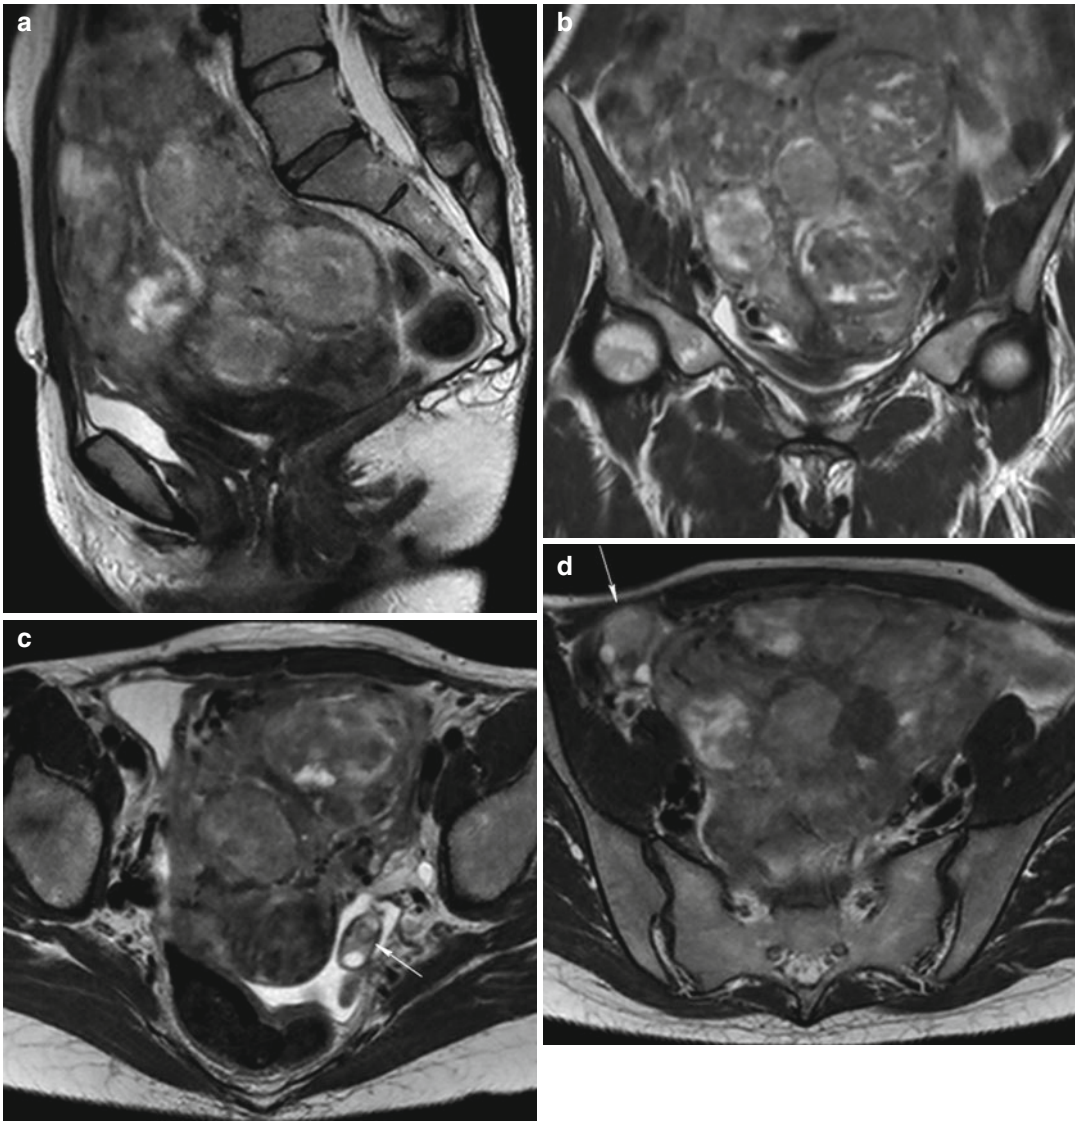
Multiple uterine leiomyomatosis. Sagittal (TR 4,800 ms, TE 80 ms) (a), coronal (TR 4,800 ms, TE 80 ms) (b), and axial (TR 5,800 ms, TE 80 ms) (c, d) T2-weighted images show a bulky and deformed uterus by the presence of multiple voluminous intramural
